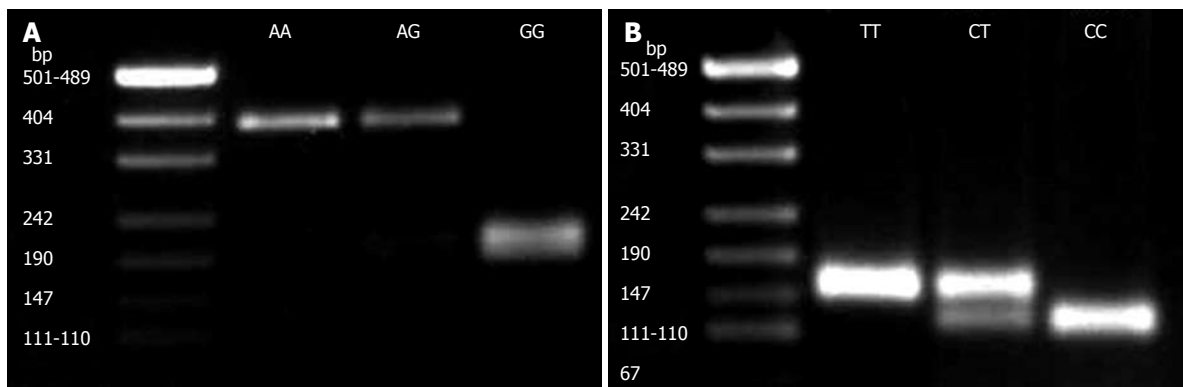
A: PCR-RFLP genotyping at position -800 (G/A). PCR product (388 bp) was digested with NmuCI restriction enzyme. From left to right: Lane 1: DNA size marker; lane 2: Homozygote AA; lane 3: Heterozygote AG; lane 4: Homozygote GG; B: PCR-RFLP genotyping at position -509 (C/T). PCR product (153 bp) was digested with Eco811 restriction enzyme. Lane 1: DNA size marker; lane 2: Homozygote TT; lane 3: Heterozygote CT; lane 4: Homozygote CC.
